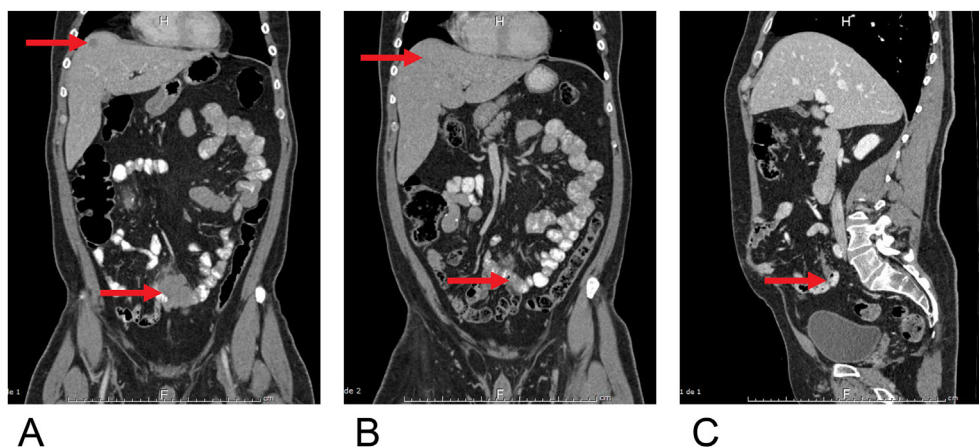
Evolution of hepatic lesion and abdominal mass on the different CT scans.
